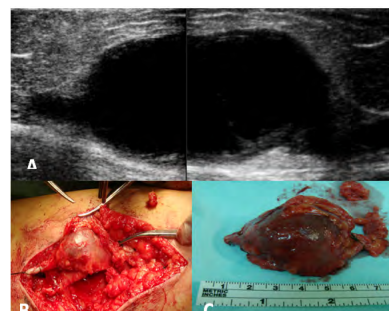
A) Reconstructed ultrasound image which shows an internal saphenous vein venous aneurysm of 9 × 5 cm B) Surgical excision of the internal saphenous vein venous aneurysms. C) Thrombosed internal saphenous vein venous aneurysm.
